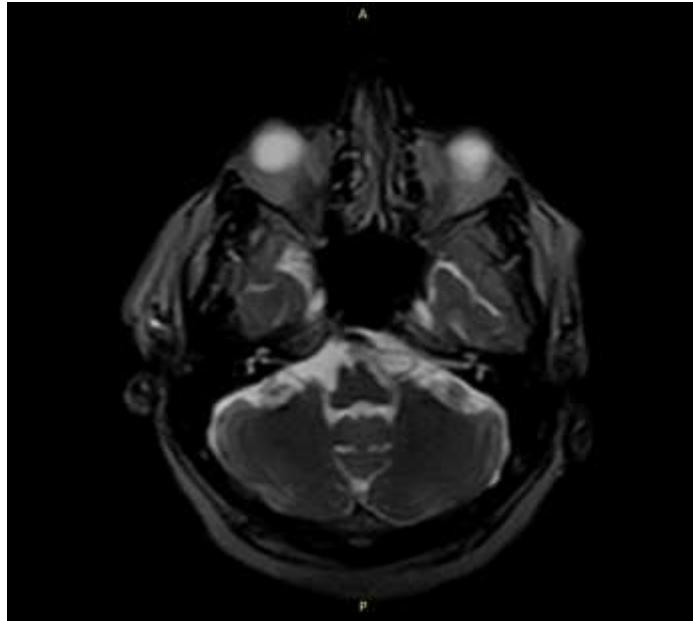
Axial MRI brain T2W image for patient number 18 shows tortuous basilar artery.
